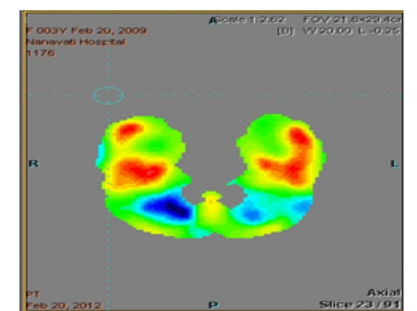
This focused slice of mesial temporal lobes show equal FDG uptake on both sides post stem cell therapy.
